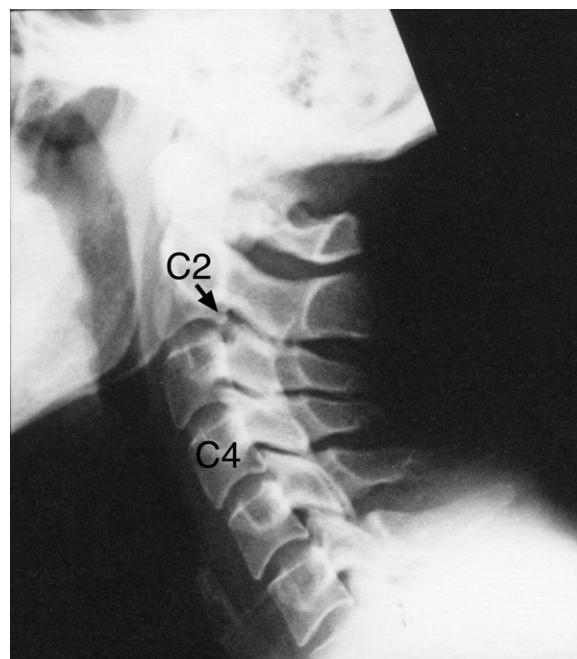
Cervical spine lateral plain X-ray image. Note (i) the slight retrolisthesis of C2 on C3 (black arrow), and (ii) the loss of normal cervical spine lordosis (with most of the lordosis taking place above the C4 level) suggesting soft tissue injuries to the neck. There is no lipping of the vertebral body margins and there is no subchondral sclerosis of the zygapophysial 'facet' joints, i.e. there is no evidence of a longstanding injury.
